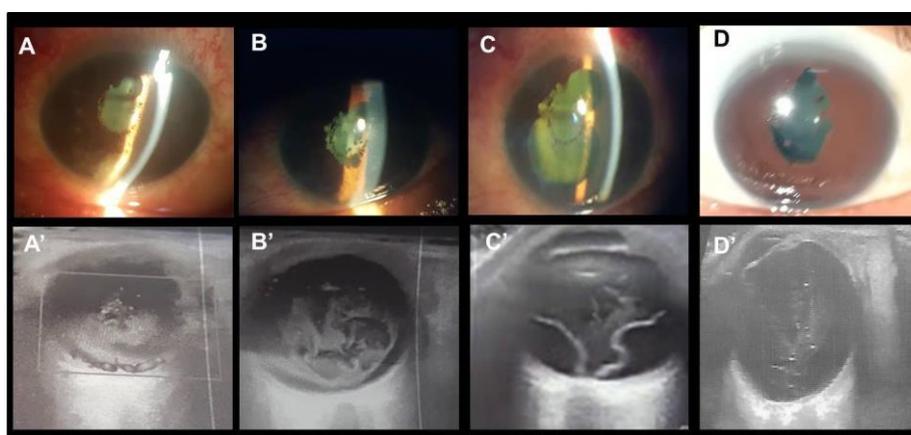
A, B, C, D. Left anterior segment photographs on the first presentation, three days, ten days, and six months after treatment respectively, revealing improvement of the inflammation. A', B', C', D'. Simultaneous ultrasonography showing dense vitreous echogenicity, the appearance of retinal detachment (C'), and its reapplication (D').
